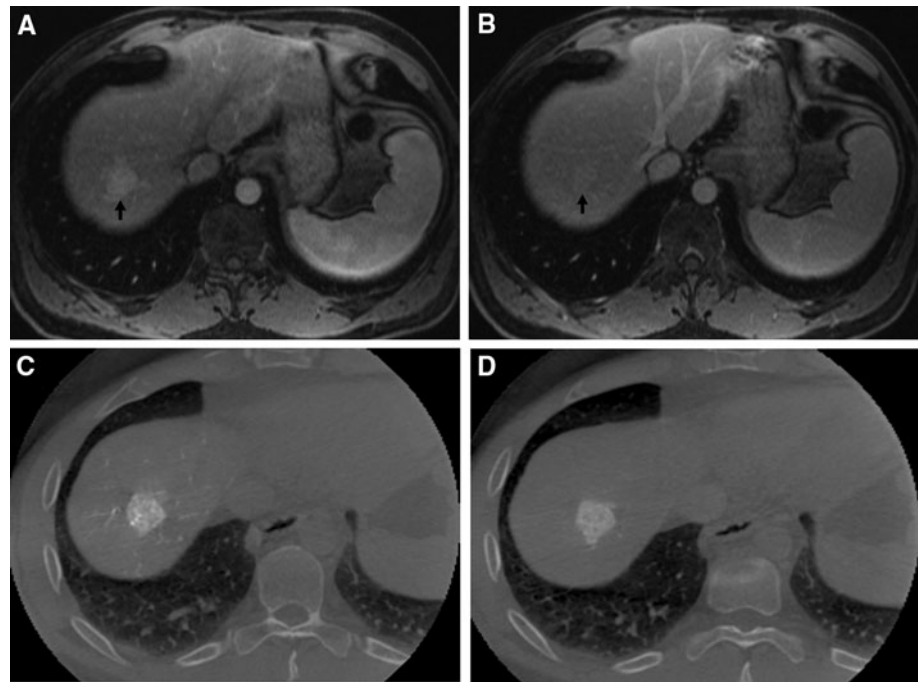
A 50-year-old male patient with unifocal HCC (Child-Pugh score 5/class A). A Preintervention conventional CE-MR image at 20 s after intravenous contrast injection shows a hyperattenuating mass in the right liver dome (*black arrow*). B This mass becomes isointense to the healthy liver tissue on delayed CE-MR image at 70 s after contrast injection. C Arterial phase dual-phase CBCTHA image before injection of DEB clearly shows the tumor without any artifacts and matching with the MRI scans. D Note how the venous phase dual-phase CBCTHA image shows clear persistent tumor enhancement. In this case, the contrast between the tumor and surrounding liver parenchyma is greater than that seen on conventional CE-MRI
